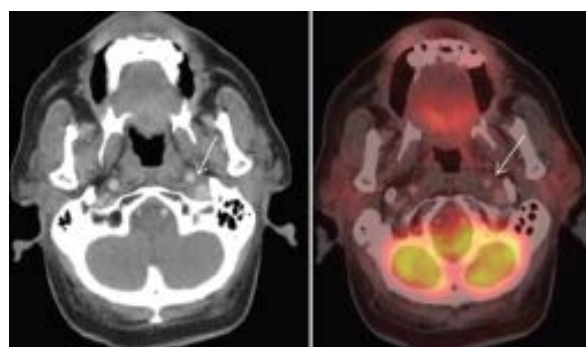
PET-CT scan done after chemotherapy shows significant interval decrease of the lesion in the left post-styloid carotid space with mild residual soft-tissue thickening (arrow in a) which shows no FDG uptake on corresponding fusion image (arrow in b), suggestive of complete metabolic response
